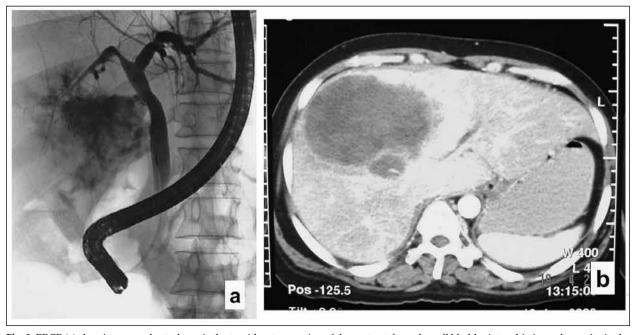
ERCP (a) showing normal extrahepatic ducts with extravasation of the contrast from the gall bladder into a big irregular cavity in the liver. CT scan (b) with i.v. contrast showing a big (11.5 x 7.7 x 11.4 cm) hypodense and inhomogenous lesion with post-contrast peripheral incomplete enhancement and non-enhancement of the center consistent with the diagnosis of an abscess cavity within the liver (segments IV,V&VI).
